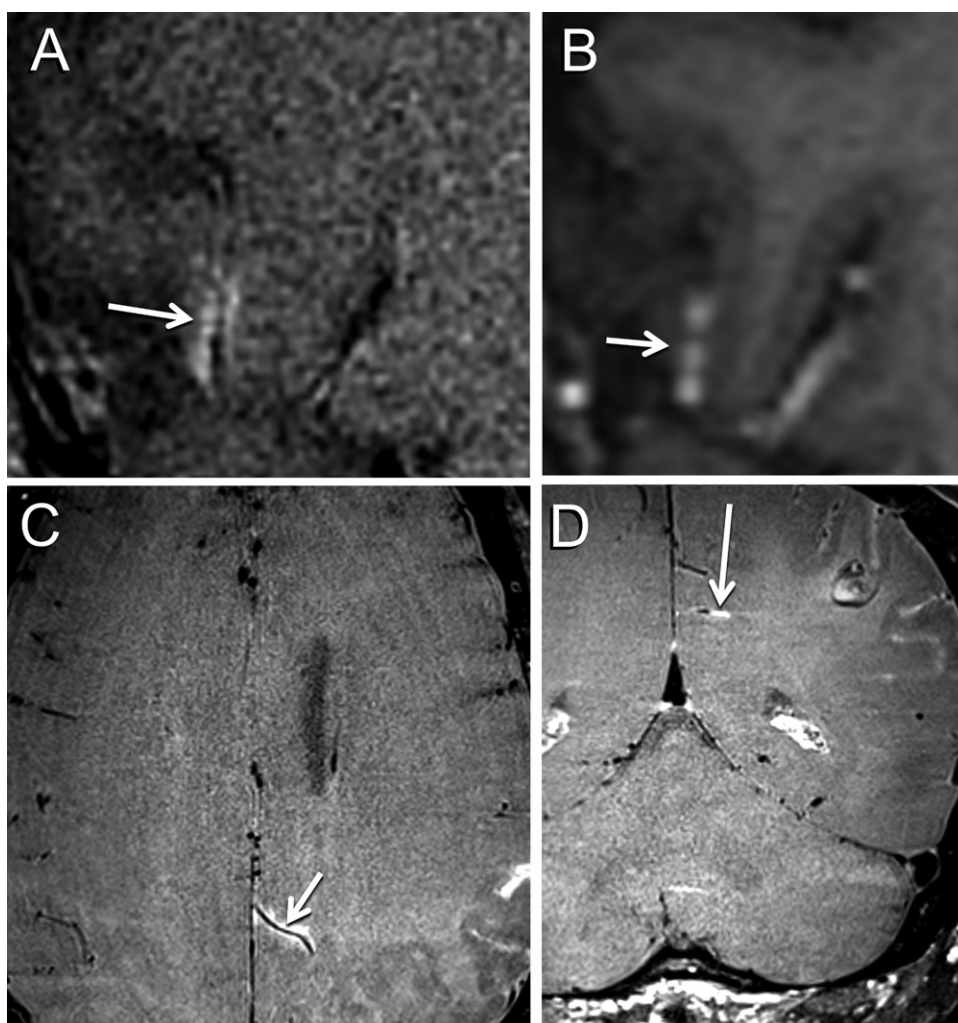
Biopsy-proven intracranial vasculitis compared with leptomeningeal enhancement mimicking this diagnosis on three-dimensional (3D) vessel wall (VW) MRI. (A, B) Coronal reconstructions of a 3D VW MRI scan in a 34-year-old man with biopsy-proven vasculitis show concentric segmental enhancement of the VW and periadventitial parenchyma involving a branch of the right middle cerebral artery (arrow in A), with corresponding irregular luminal enhancement on 3D postcontrast T1-weighted brain image (arrow in B). (C) In contrast, postcontrast axial VW MRI in a 69-year-old woman with left parietal intracerebral hemorrhage and prior stroke shows prominent perivascular enhancement surrounding a vessel in the left inferior parietal lobe (arrows). (D) Postcontrast coronal VW MRI scan shows enhancement is leptomeningeal, confined to a sulcus oriented along an axial plane, and does not involve brain parenchyma.
